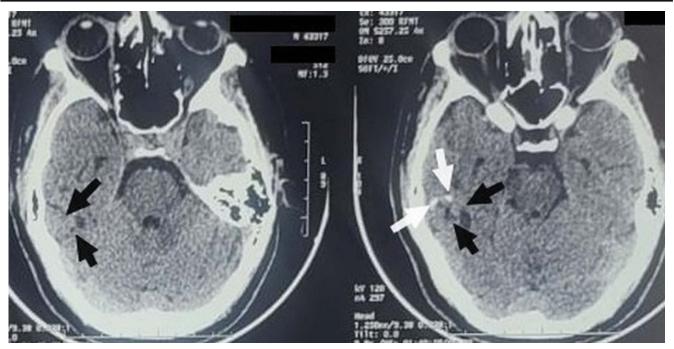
A non-enhanced brain computed tomography scan in axial plane and parenchymal window showing a right temporal lesion of heterogeneous density (black arrows) harboring small calcifications (white arrows).
